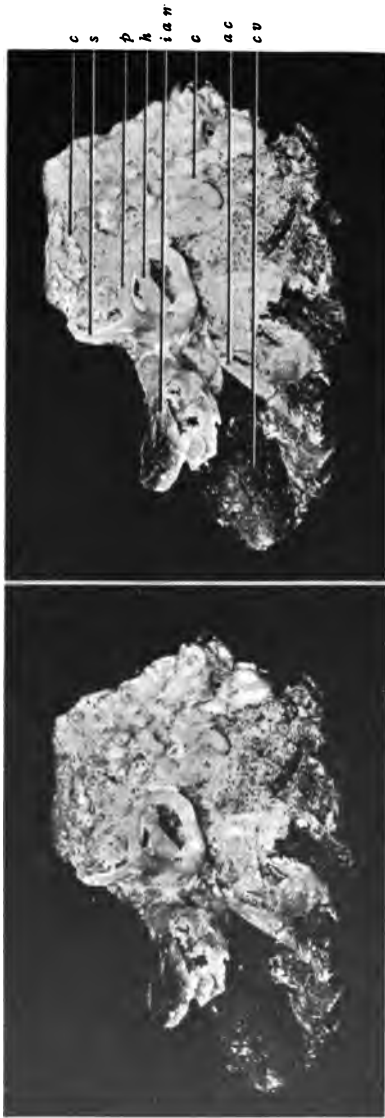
CAST OF THE CAVITIES OF THE TEMPORAL BONE: VIEWED FROM THE INNER ASPECT AND BEHIND. NATURAL SIZE.
